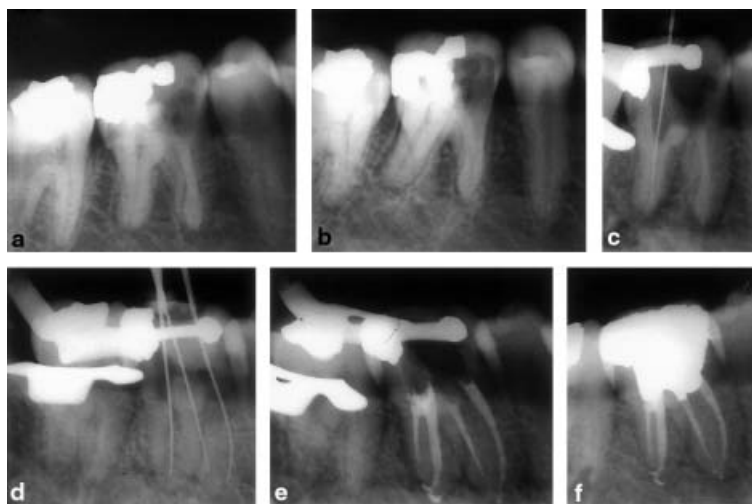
(a) Radiograph of tooth 46 showing decay and fracture of the mesiobuccal cusp. (b) A second preoperative radiograph of tooth 46 taken with a more mesial angulation and revealing the presence of a lingually located additional distal root. (c) Length-determination radiograph of the root canal in the radix entomolaris. (d) Length-determination radiograph of the conventional root canals (one distal root canal and two mesial canals). (e) Radiographic control following obturation of the four root canals. (f) Radiographic control 1 year postoperatively revealing a continuous periodontal space with no signs of periapical periodontitis.
